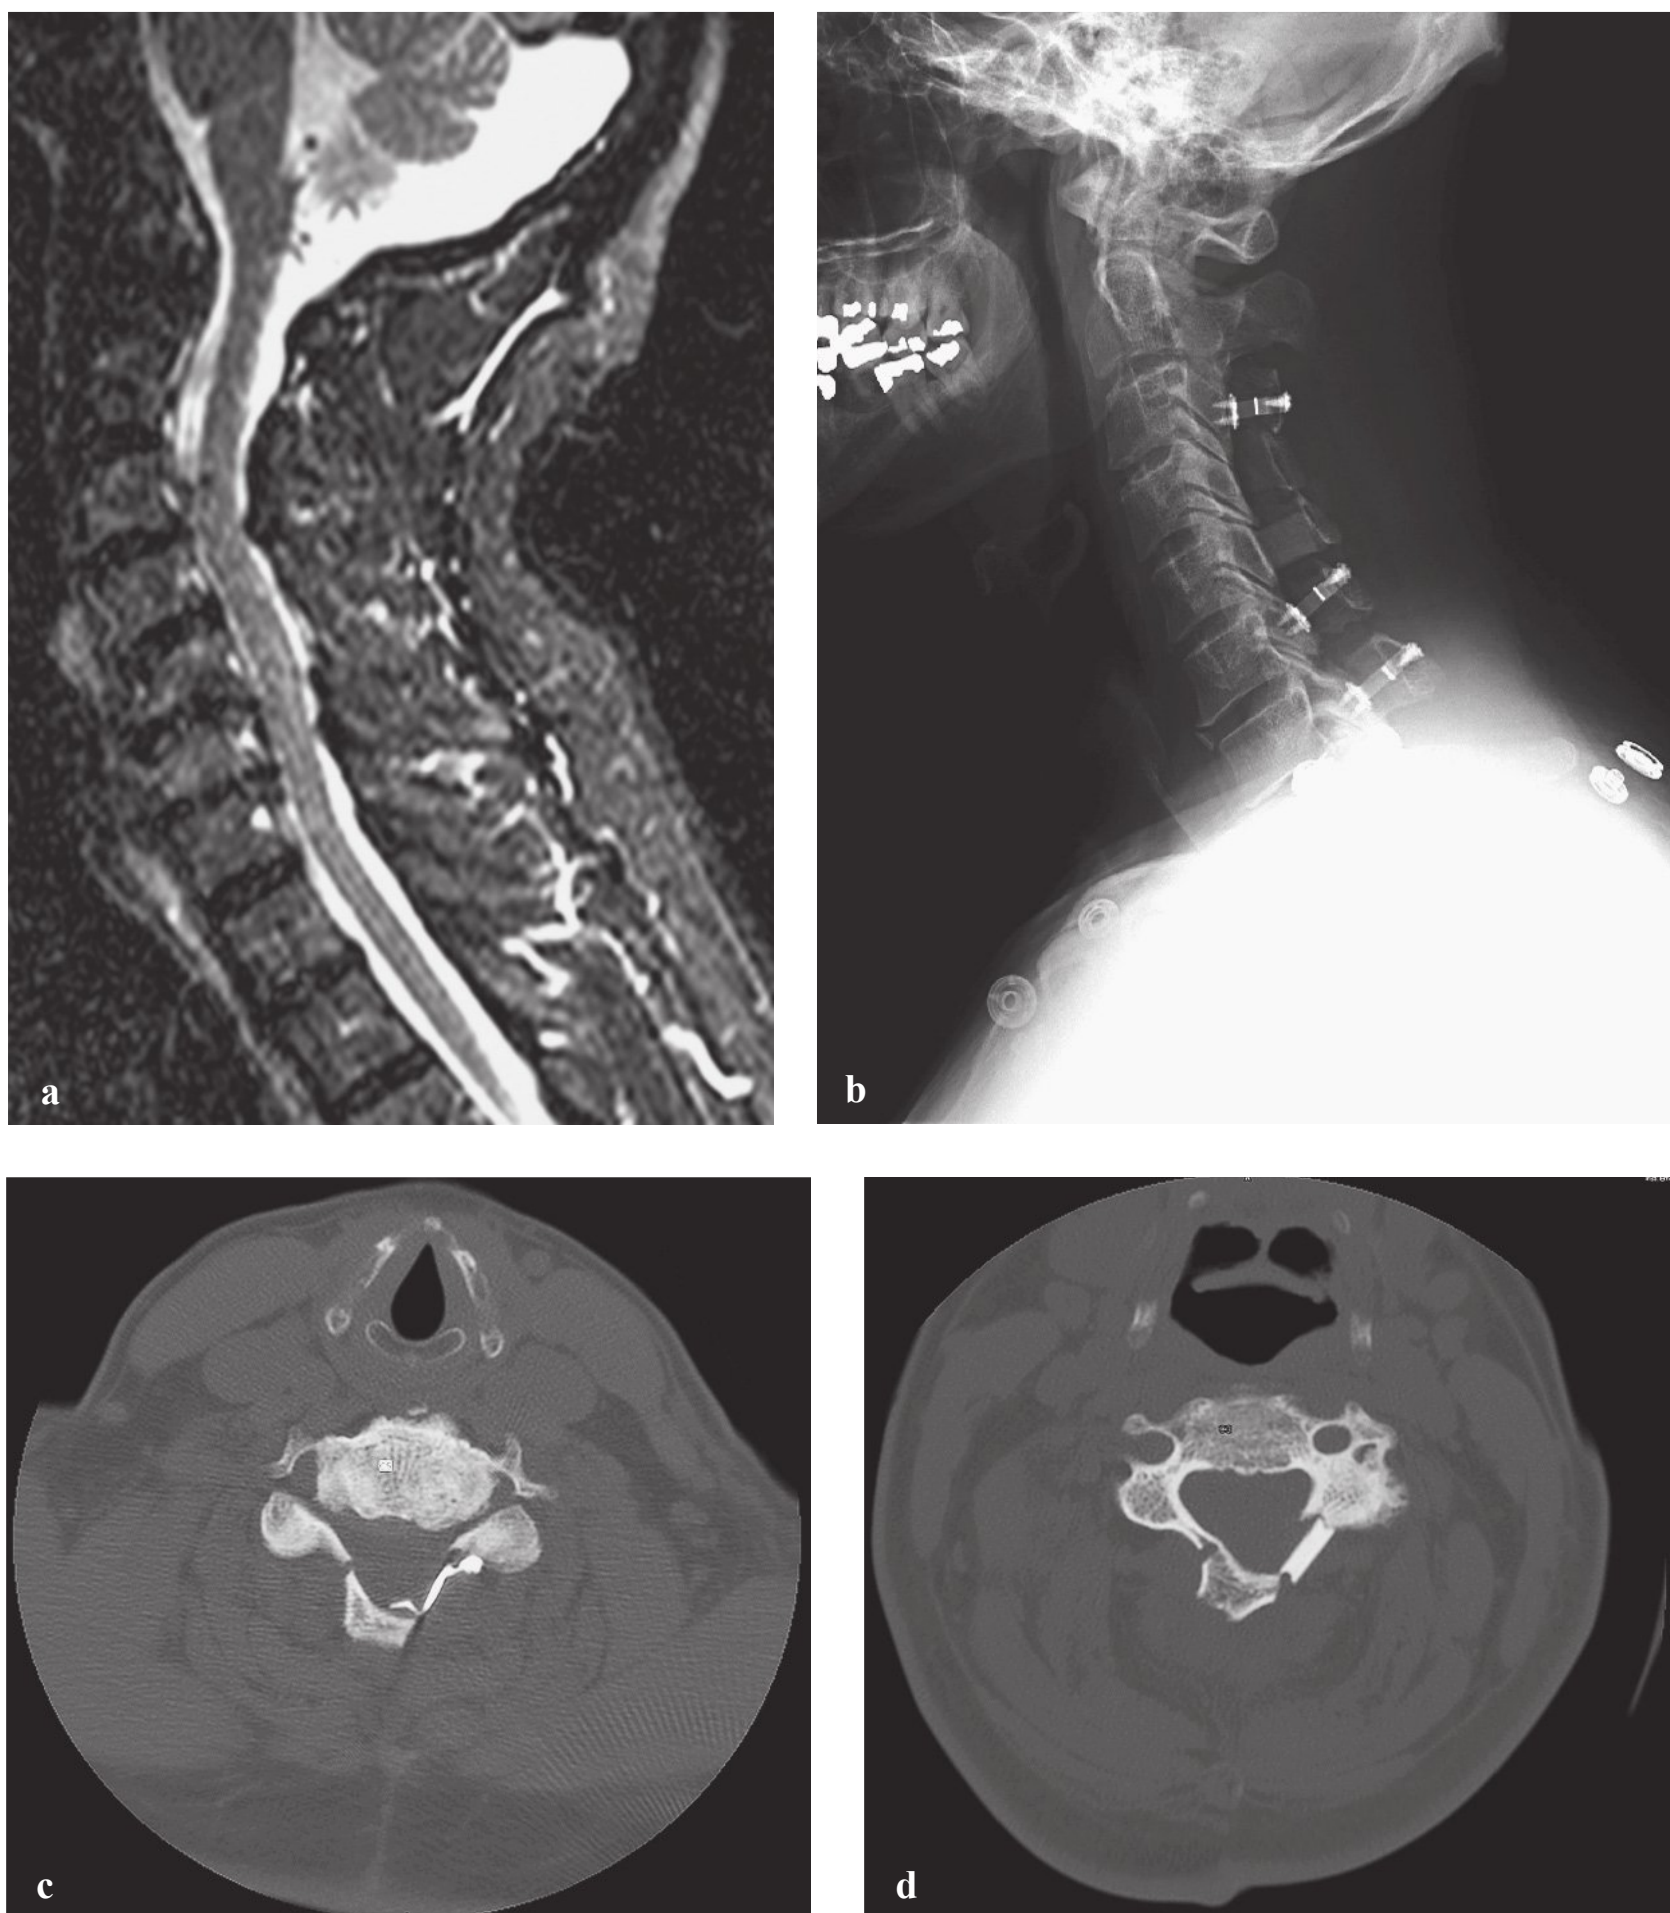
(a) Preoperative cervical magnetic resonance imaging demonstrating spinal stenosis extending from C3 to C7. (b) A laminoplasty from C3 to C7 was performed (postoperative lateral radiograph demonstrating the placement of titanium cervical plates and allograft). (c) Postoperative axial computed tomography demonstrating placement of the titanium plate. (d) Postoperative axial computed tomography demonstrating placement of the machined allograft.
